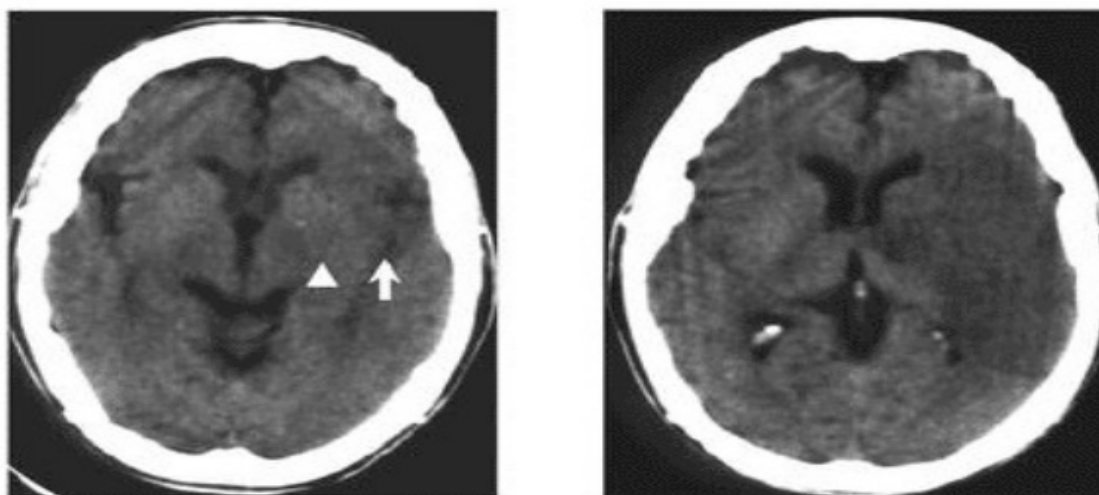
CT 12 hrs and 36 hours after onset of left MCA territory infarct
